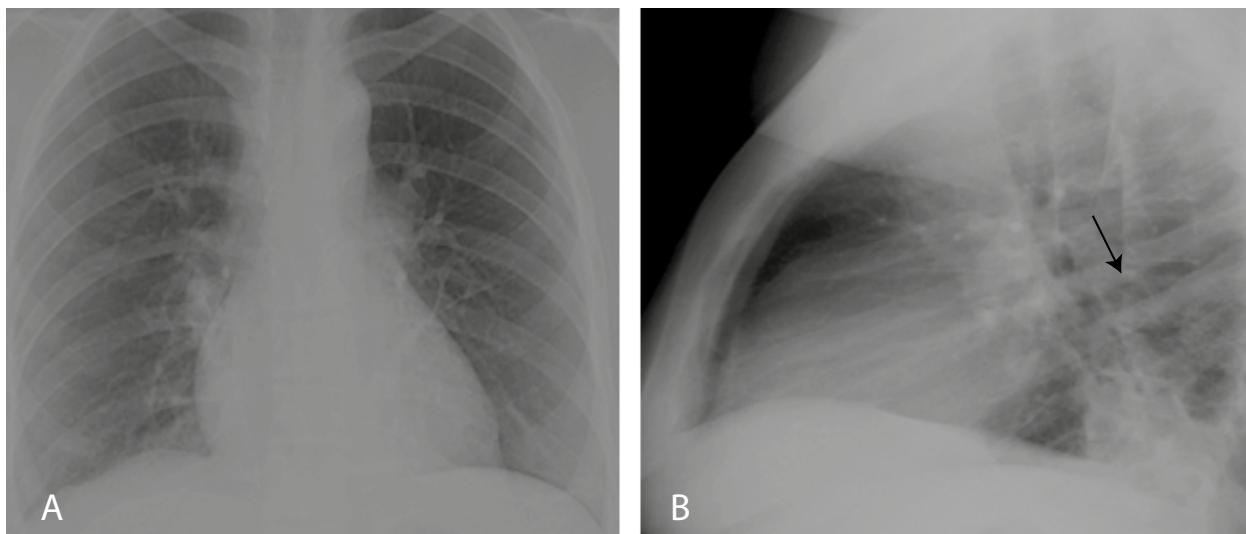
Chest X-ray on patient's admission. A) anteroposterior plane without evidence of relevant alterations; B) lateral plane with segmental atelectasis.
